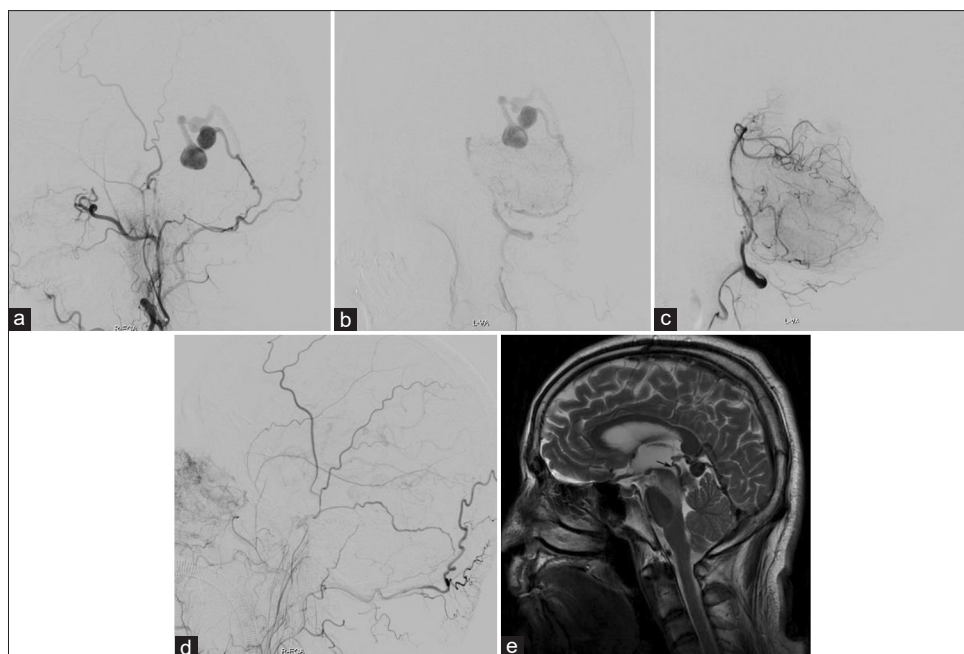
A 54-year-old man who had chronic headaches. The right external carotid artery (a) and the left vertebral artery (b) angiograms showing a dural AVS of the tentorial with large venous pouch fed by the right middle meningeal and left posterior auricular arteries. The right external carotid artery (c) and the left vertebral artery (d) angiograms after Onyx embolization revealing complete obliteration of the fistula. (e), sagittal MRI scan, T2-weighted, demonstrating precentral vein (arrow) and venous pouch thrombosis and mesencephalic edema
